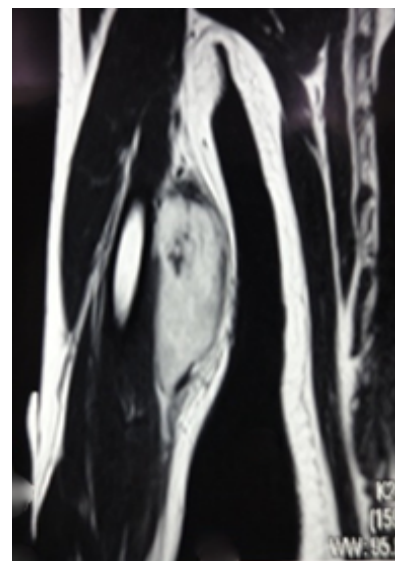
MRI right arm showing soft tissue swelling in relation to triceps muscle.
